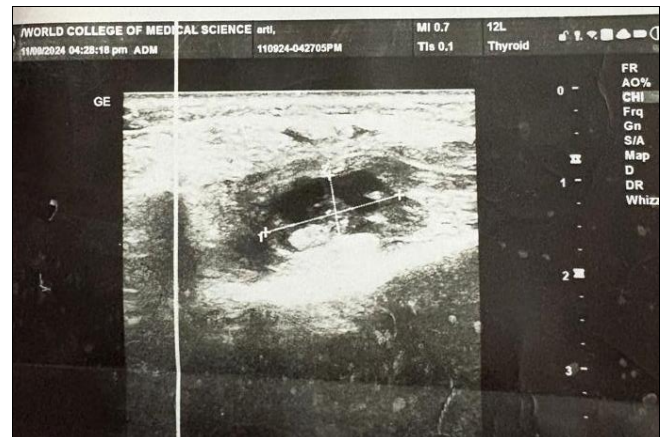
Ultrasonography showed a cystic lesion measuring 1.6x0.8cm within intermuscular plane showing internal echogenic content, anteromedial to left mandibular ramus likely involving Masseter muscle. ?Myocysticercosis with scolex
